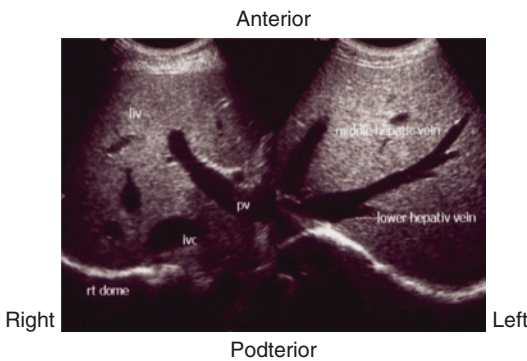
B-mode/2D image in ultrasound
